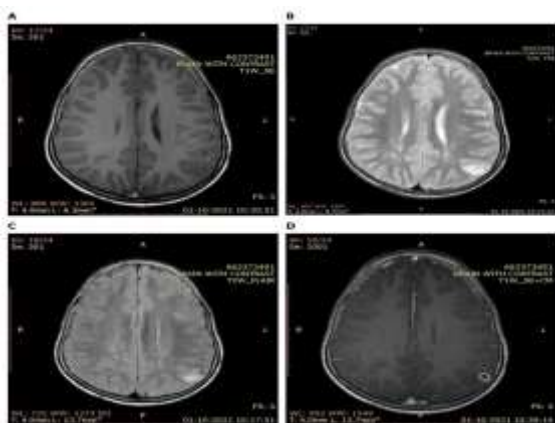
MRI findings of inflammatory granuloma.
